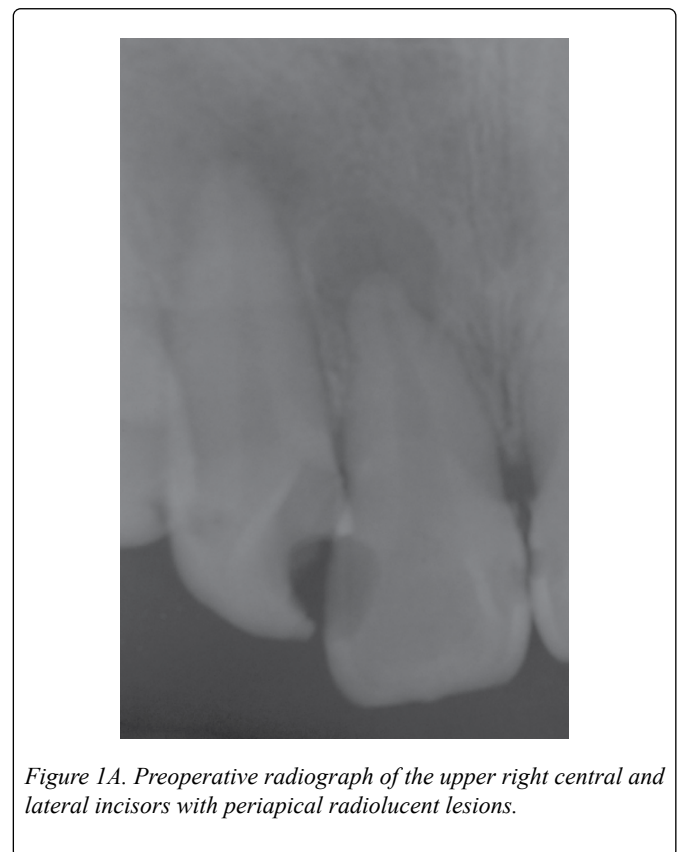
Preoperative radiograph of the upper right central and lateral incisors with periapical radiolucent lesions.
